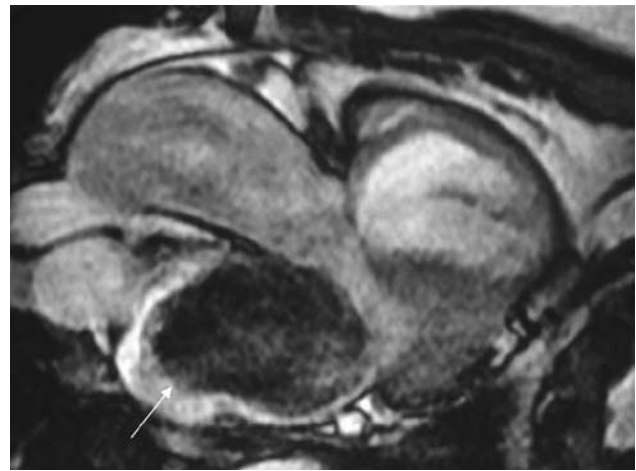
MRI: Left atrium myxoma.
